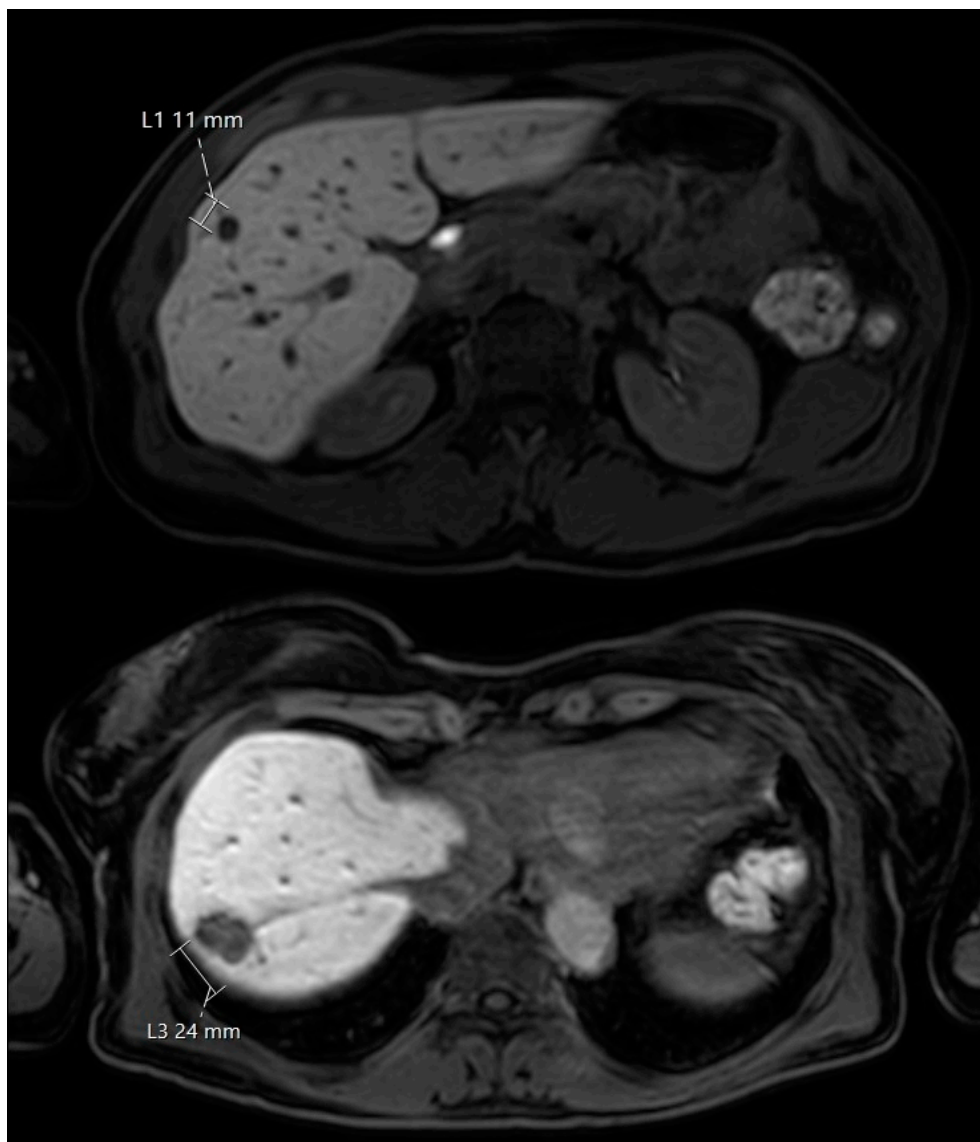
MRI demonstrates findings consistent with metastatic colorectal carcinoma. An 11 mm metastatic lesion is identified in hepatic segment IV (upper image). A second metastatic lesion of 24 mm is visualized in hepatic segment VII (lower image). The images were obtained by the attending surgeon, Dr Hanna Sternby, with the patient's informed consent.
